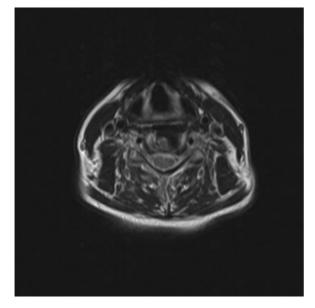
T2-weighted axial magnetic resonance imaging at the C5–C6 level confirming no persistent and/or recurrent stenosis impinging upon the affected left C6 nerve root.
